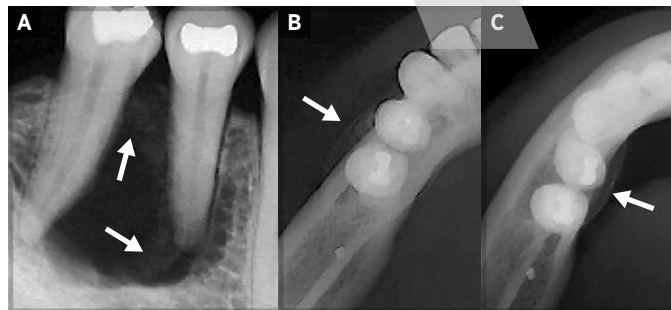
Initial radiographic presentation of the lesion. A. Mineralized tissue in the distal region of the mandibular first premolar (arrows). B. Vestibular cortical expansion (arrow). C. Lingual cortical expansion (arrow).
